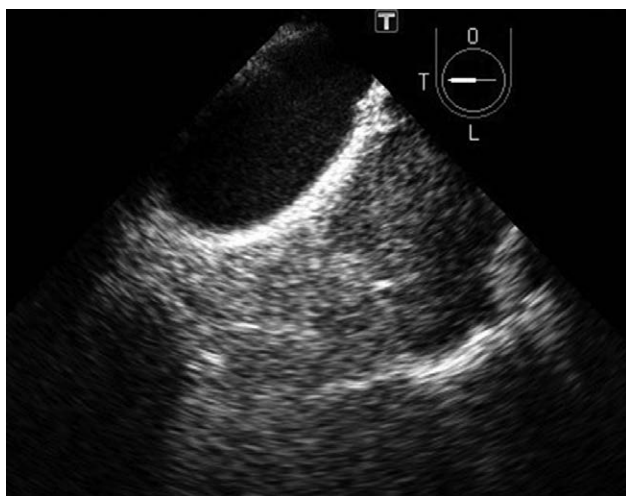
Intraoperative transesophageal echocardiography showing a preserved endothelial border and an unclear adventitia border.
